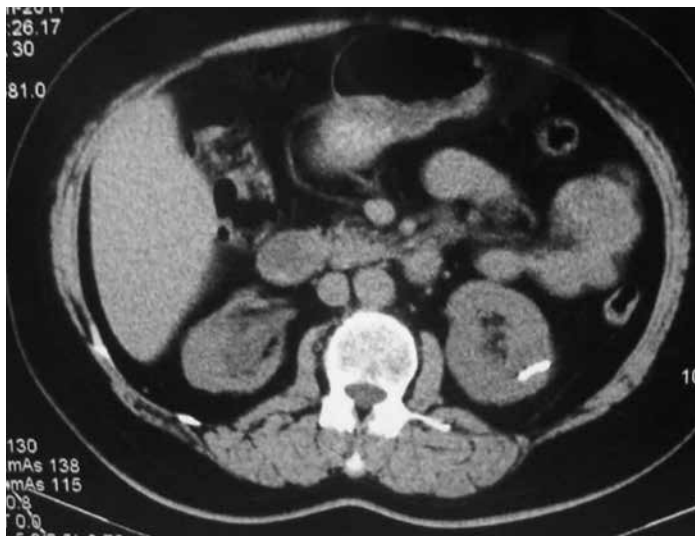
Catheter in the cyst wall, posterior to the kidney in abdominal computed tomography
